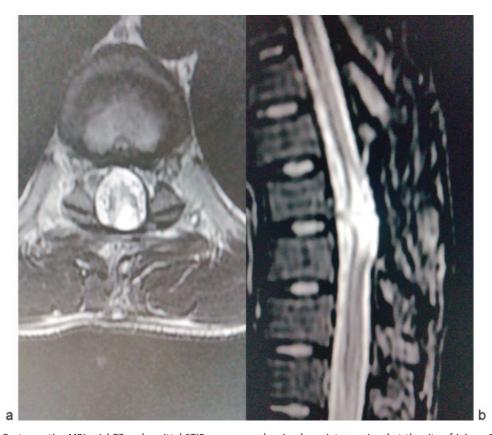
(a and b) Postoperative MRI axial T2 and sagittal STIR sequences showing hyperintense signal at the site of injury, 15 months after surgery.
